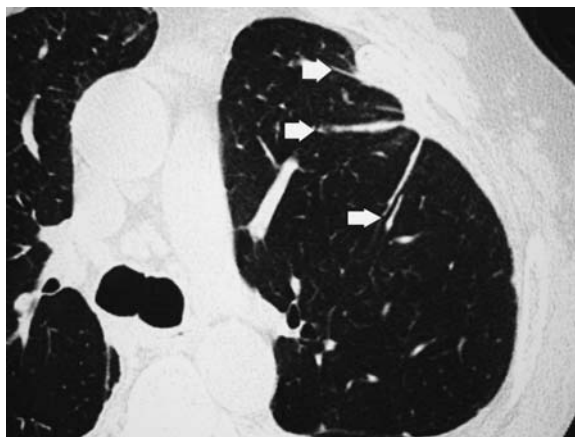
Thin-section computed tomography showing multiple parenchymal bands arising from a single point of thickened pleura likened to 'crow's feet' (arrows)
